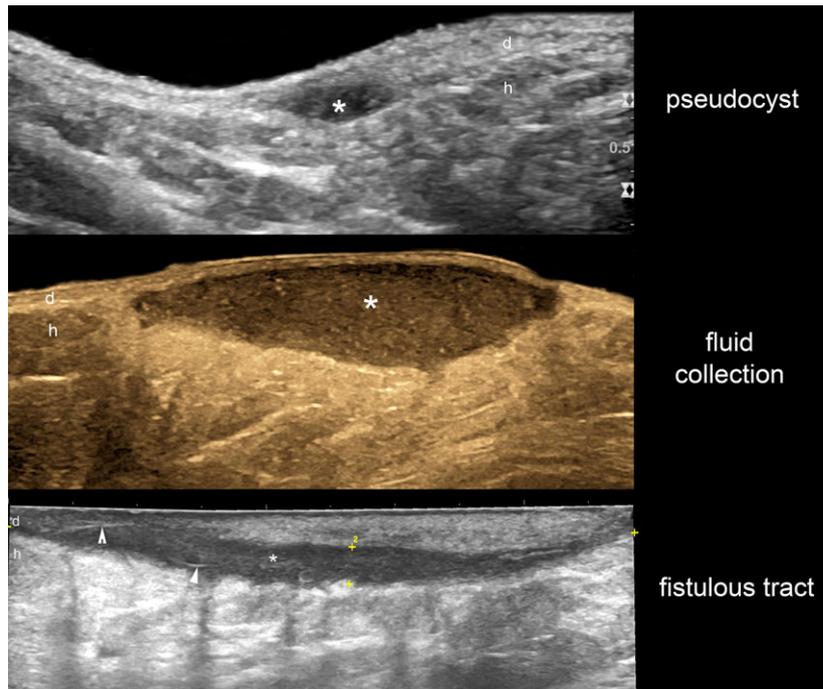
Sonographic main type of lesions (*pseudocyst, fluid collection, fistulous tract) in pediatric hidradenitis suppurativa. d, dermis; h, hypodermis. Arrowheads mark retained small hair tract fragments within the fistulous tracts.
